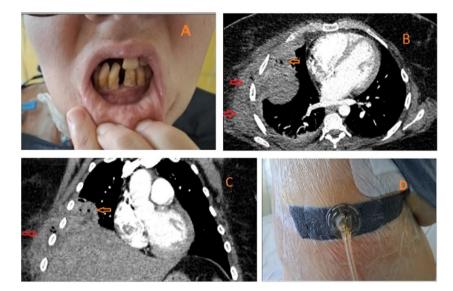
(A) Severe gingival retraction with pyorrhea and missing teeth. (B, C) Chest CT, axial and coronal images. Necrotic atelectasis of the middle and lower lobe (orange arrows), contiguous to a heterogeneous hyperdensity with mass effect in the chest wall (red arrows). Gas is seen within both lesions. (D) On day 3 after surgery, negative pressure wound therapy was applied with the use of 3MTM ActiV.A.C.TM device to accelerate the scarring process.
